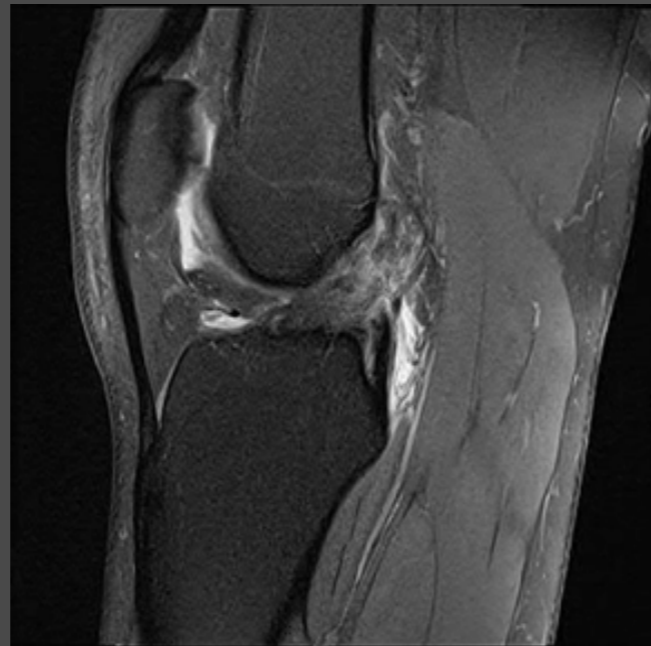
Patient A- MRI showing a complete anterior cruciate ligament (ACL) tear.
